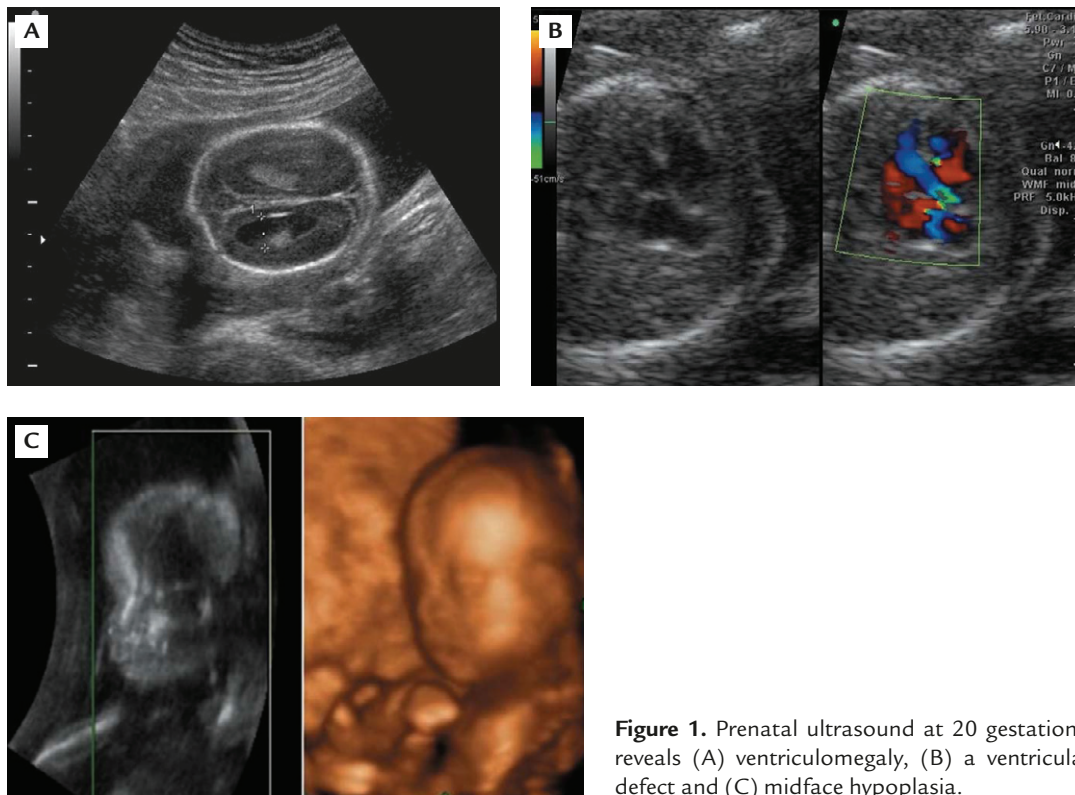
Prenatal ultrasound at 20 gestational weeks reveals (A) ventriculomegaly, (B) a ventricular septal defect and (C) midface hypoplasia.
